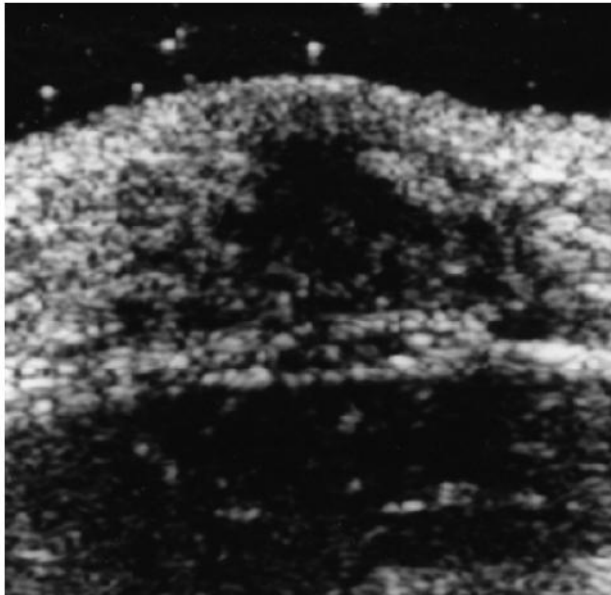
An ultrasound (US) of a 13 year-old boy with gynecomastia, showing breast development
